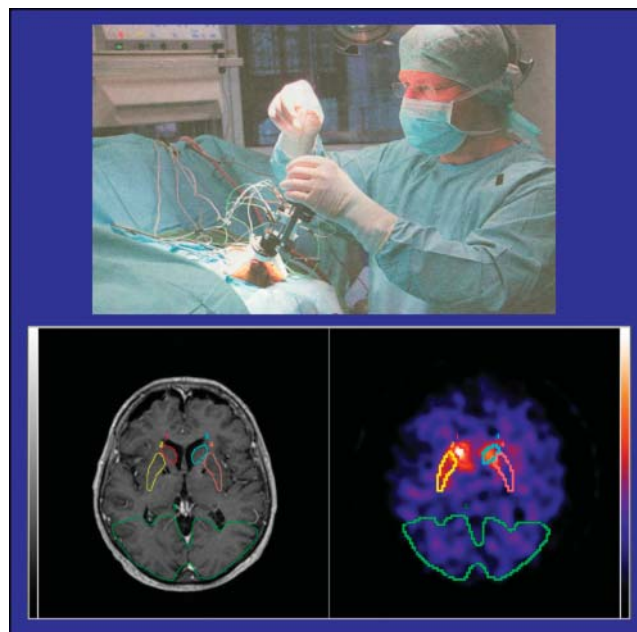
¹²³I-FP-CIT and ¹²³I-iodobenzamide SPECT (superimposed with MR data, bottom) were used to assess the long-term effects of surgical deep brain stimulation of the subthalamic nucleus (top) on striatal dopaminergic transmission in patients with advanced Parkinson's disease.
